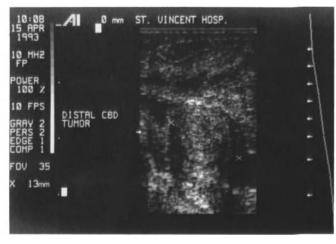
Ultrasound view of a patient with a tubovillous adenoma in the distal common bile duct. Note that the adenoma is solid with internal echoes and no posterior shadowing. The tumor measures 13 mm. This patient had high-grade dysplasia with no evidence of invasive adenocarcinoma.
